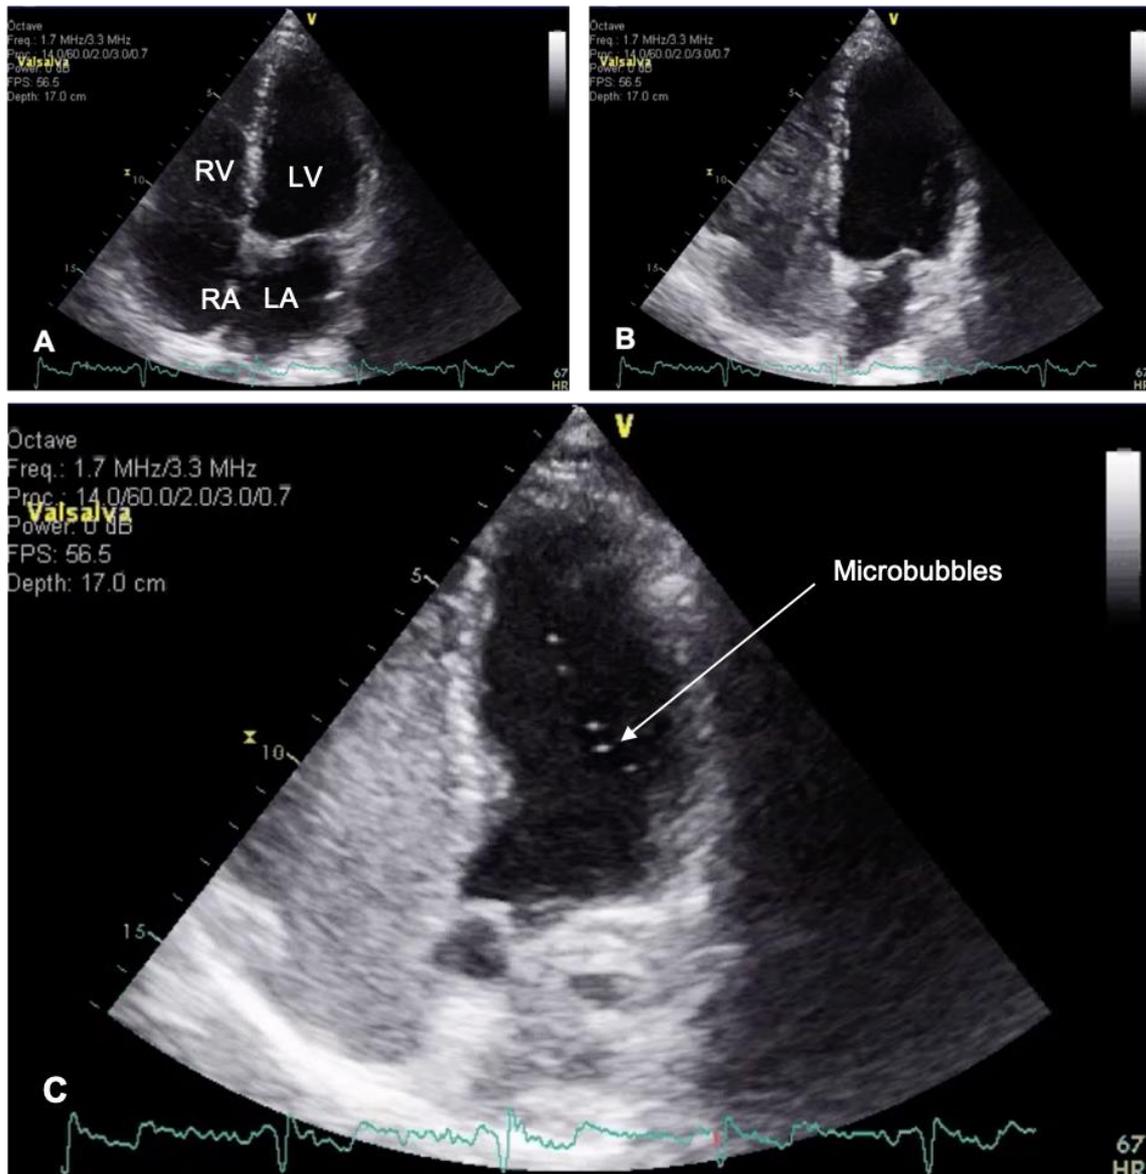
(A) Transthoracic echocardiogram four chamber view of the heart at rest prior to the agitated saline injection. (B) Opacified right heart during the agitated saline injection. (C) Multiple microbubbles indicated by the arrow can be seen in the left atrium and some have moved into the left ventricle following the release phase of the Valsalva manoeuvre. Abbreviations: TTE = transthoracic echocardiography, RV = right ventricle, LV = left ventricle, RA = right atrium, LA = left atrium. Image obtained with permission from the Southern District Health Board.
